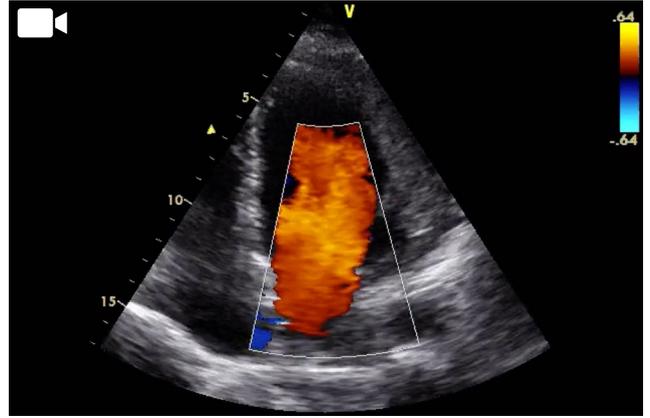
(a) Intraoperative view of aspiration of cystic fluid. (b) Removal of cyst material through an incision made in the anterior aspect of the heart. (c) Removed cyst material. (d) Repair of the ventricular incision with the capitonnage technique similar to aneurysm repair. (e) Apical four-chamber view on transthoracic echocardiography after cardiac cyst removal. (f) Short axis view on transthoracic echocardiography after cardiac cyst removal.
